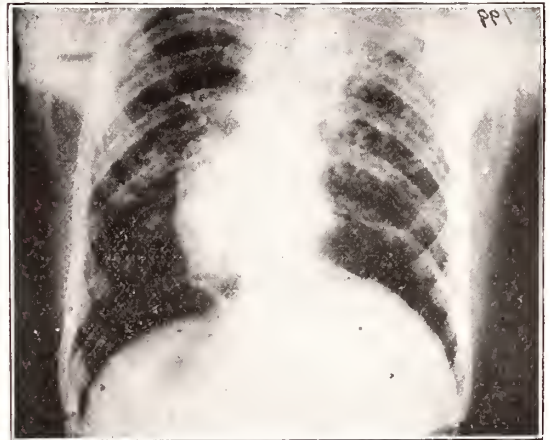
Radiograph showing advanced pulmonary tuberculosis with cavity formation in the right upper lobe.
